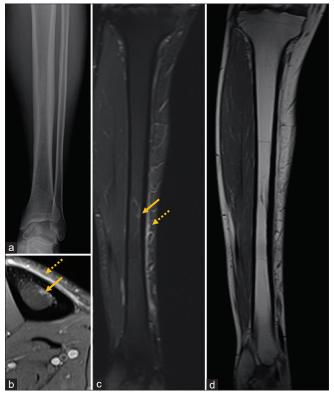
A 26-year-old with shin pain showing Grade 2 MTSS. (a) Radiograph was normal. (b and c) Axial and coronal STIR images show hyperintense periostitis (dashed arrow) with subtle marrow edema (arrow) in mid-tibial shaft (separate from the nutrient artery). (d) Coronal T1W image does not show any significant marrow edema or fracture line.
